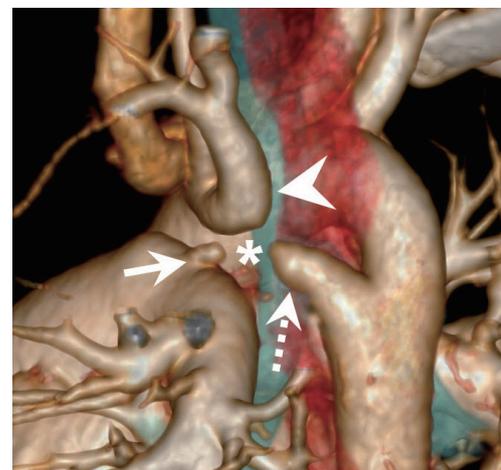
Multi-detector row computed tomography image of Case 2. Posterior volume rendering image. Proximity of posteroinferiorly distorted left subclavian artery (arrowhead), descending aortic diverticulum (dashed arrow) and pulmonary artery pouch (arrow) suggests fibrous connection (*) among these structures, and demonstrates double aortic arch with atretic left aortic arch distal to origin of left subclavian artery.
